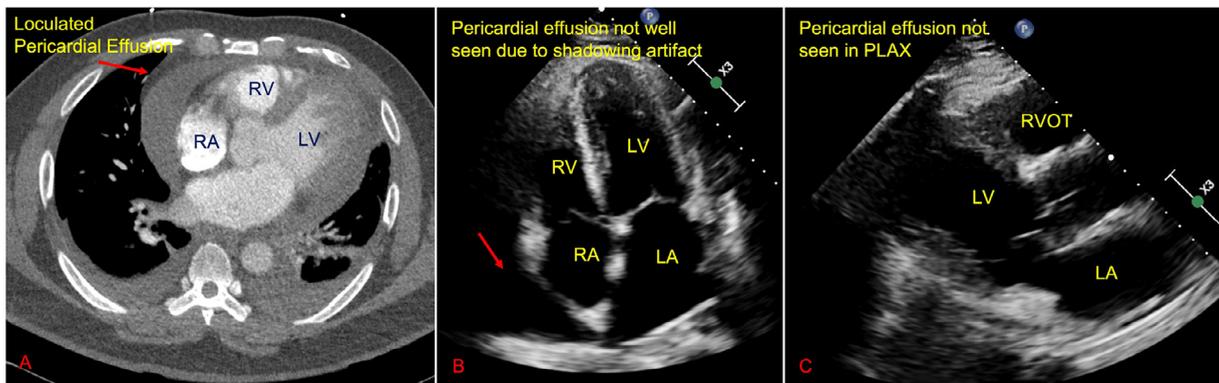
Loculated effusion seen on CT but not well seen on transthoracic echocardiogram apical 4 chamber view because of shadowing artifact near the right atrium. The effusion is not present in the parasternal long-axis view. LA = left atrial; LV = left ventricular; RA = right atrial; RV = right ventricular; RVOT = right ventricular outflow tract
